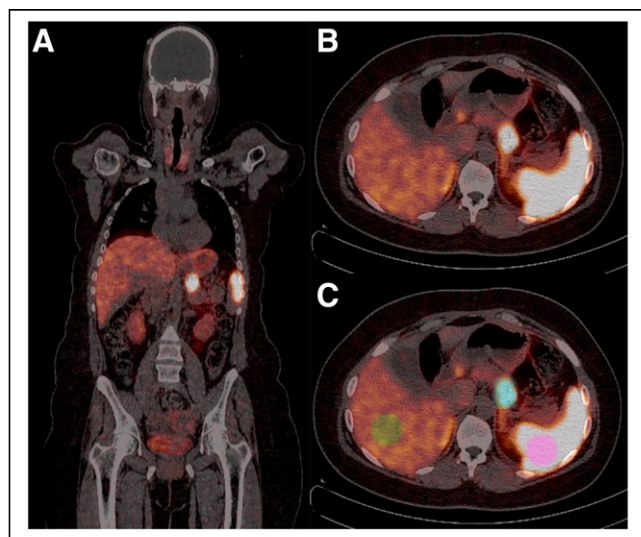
⁶⁸Ga-DOTATOC PET/CT in patient with pancreatic NET. (A) Coronal image showing primary tumor. (B and C) Transaxial images of same section without (B) and with (C) overlay of VOIs drawn around primary tumor (blue VOI), within normal liver (green VOI), and within normal spleen (pink VOI).
